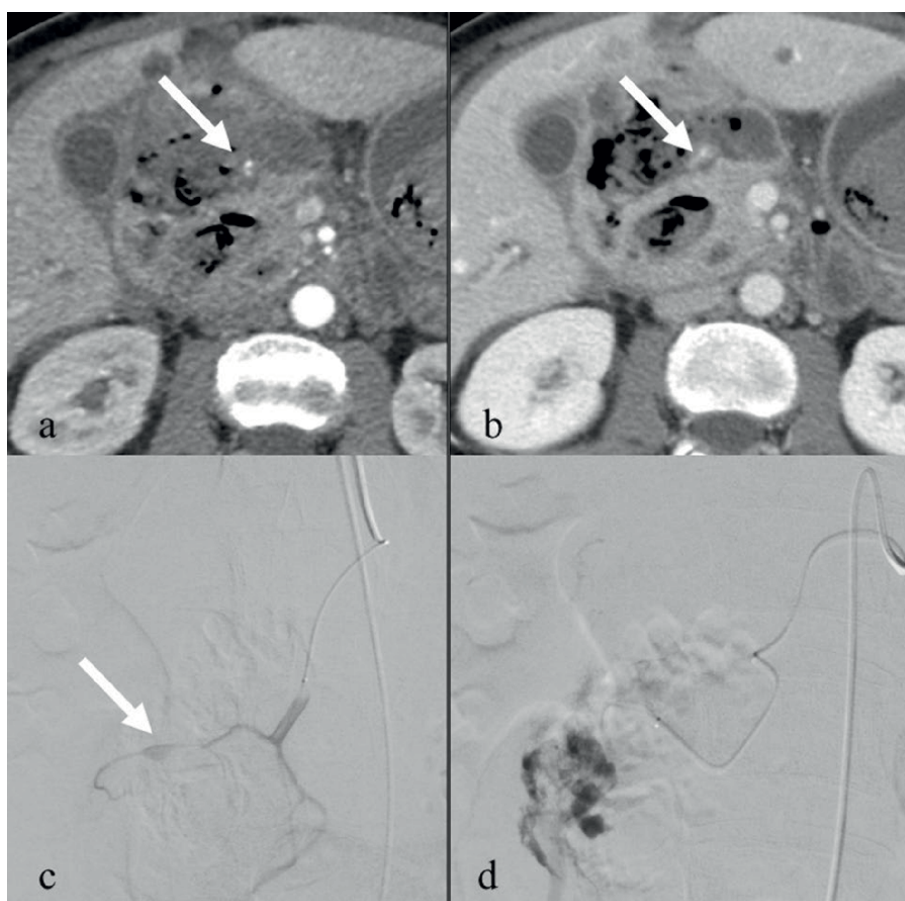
F, 56 yo with upper gastrointestinal bleeding a month after acute pancreatitis onset; CT detected a pseudoaneurysm of the superior pancreaticoduodenal artery due to walled-off necrosis (a, b). The patient underwent an emergent percutaneous angiography that confirmed the extravasation of the contrast medium (c) and selective embolization of the culprit branches (d).
